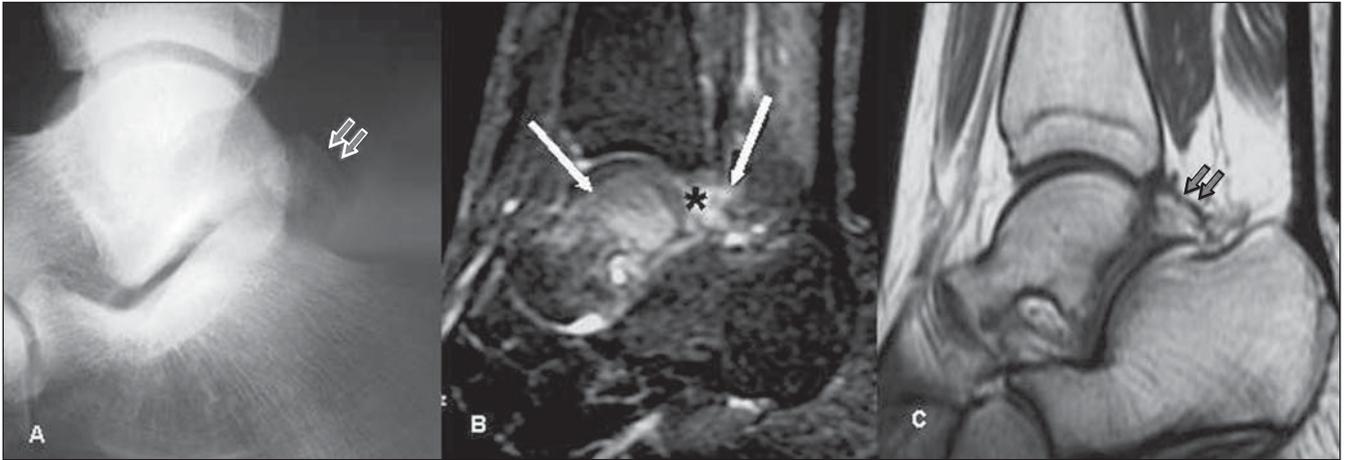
Lateral ankle radiography (A), sagittal STIR MRI sequence (B), and T1-weighted (C) images demonstrating the presence of *os trigonum* (double arrows) with bone marrow edema. Additionally, bone marrow and soft tissues edema is observed in the posterior portion of the talus (long arrows), between the posterior rim of the tibial epiphysis (double arrows) and the *os trigonum* (asterisk).
